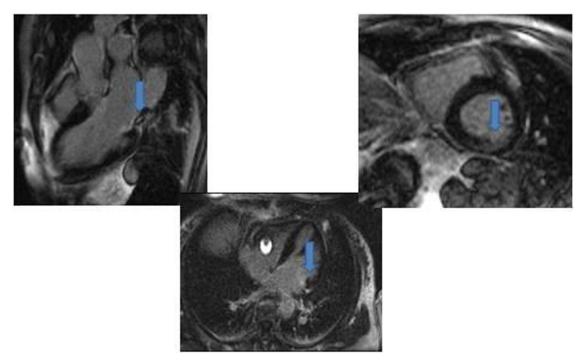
Contrast magnetic resonance imaging study of the left ventricle: delayed enhancement (suggesting fibrosis) of the inferior-basal left ventricular wall at the insertion of the posterior papillary muscle (*arrow*).
